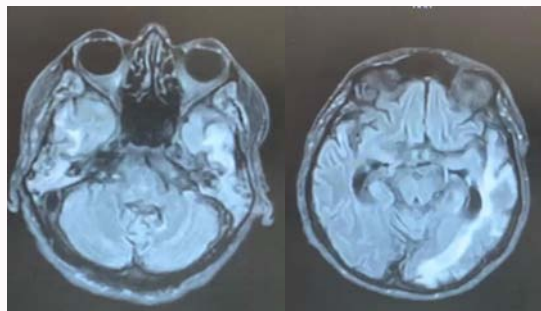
Skull MRI showing altered cortical-subcortical intensity of the temporal lobes, hyperintense on T2 and FLAIR, notably on the left.
